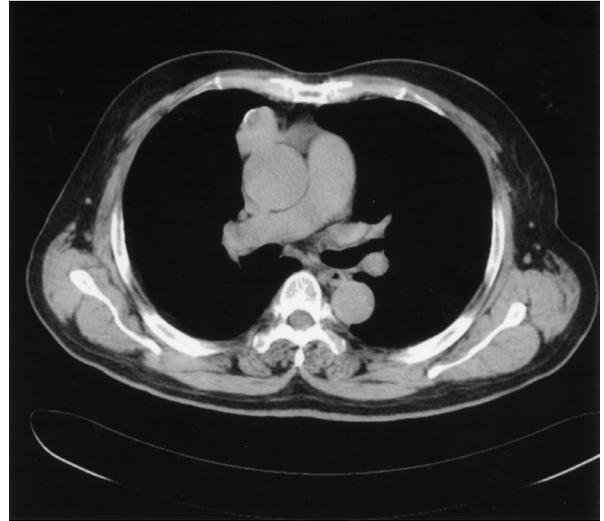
Chest CT scan showing a soft tissue density in the right anterior mediastinum with calcification.
